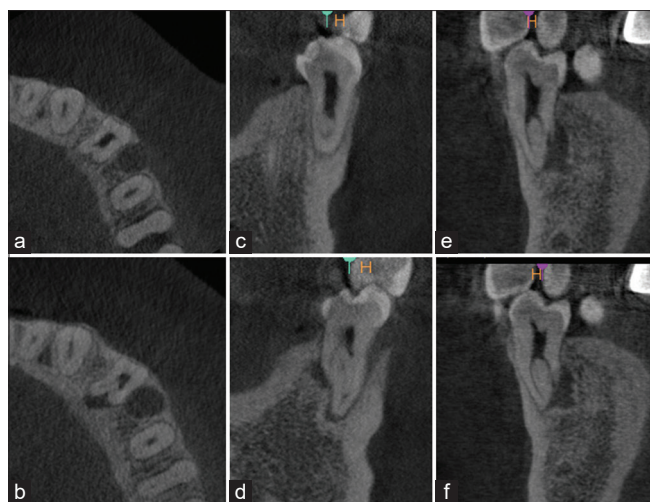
Cone beam computed tomography for tooth #34. (a) Axial view from the middle third showing the canal bifurcation with distal radiolucency. (b) Axial view from the apical third showing the C-shaped canal configuration with lingual and distal radiolucency. (c) Coronal view from the mesial aspect showing the low bifurcation of the main canal. (d) Coronal view from the distal aspect showing the extra fused root. (e) Sagittal view from the buccal aspect showing clearly the bifurcation of the main canal with distal radiolucency. (f) Sagittal view from the lingual aspect showing the extra canal with associated radiolucency
